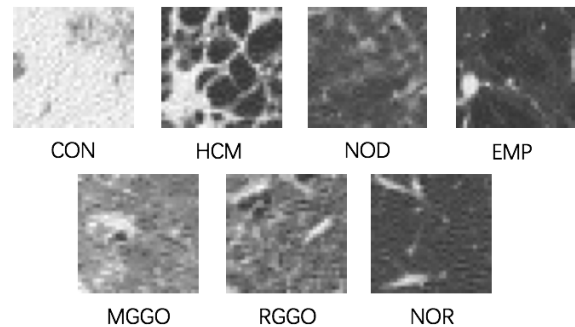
Examples of pulmonary textures on CT images. They are consolidation (CON), honeycombing (HCM), nodular opacity (NOD), emphysema (EMP), multi-focal ground-glass opacity (M-GGO), reticular ground-glass opacity (R-GGO) and normal pulmonary tissues (NOR).
